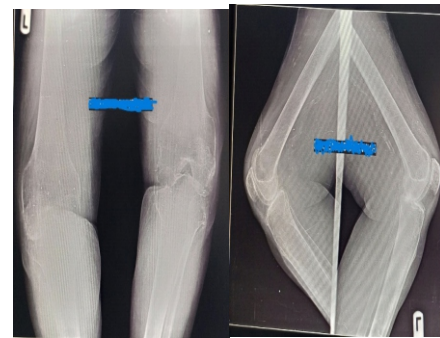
Pre-operative anterior-posterior and lateral x-ray films of both knees.
